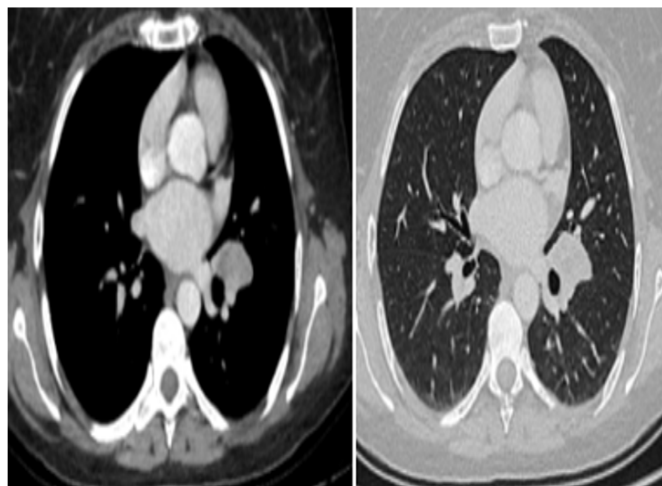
Thoracic computed tomography (CT) showing a well-circumscribed mass (37×29 mm) in the left hilum encircling the basal branch of the lower lobe pulmonary artery, with a 15×11 mm subcarinal lymph node
